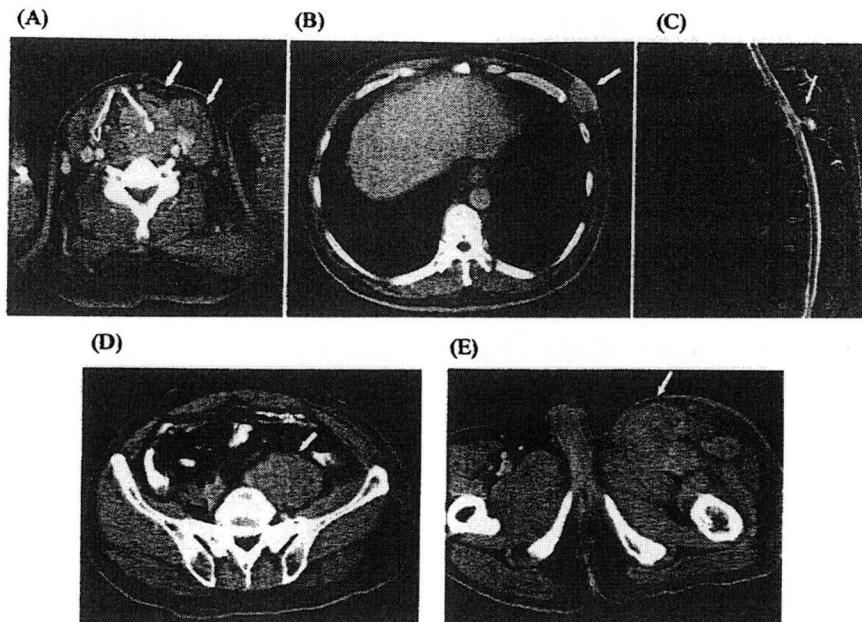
初診時での頸部～骨盤 CT 検査および胸椎 MRI 検査
